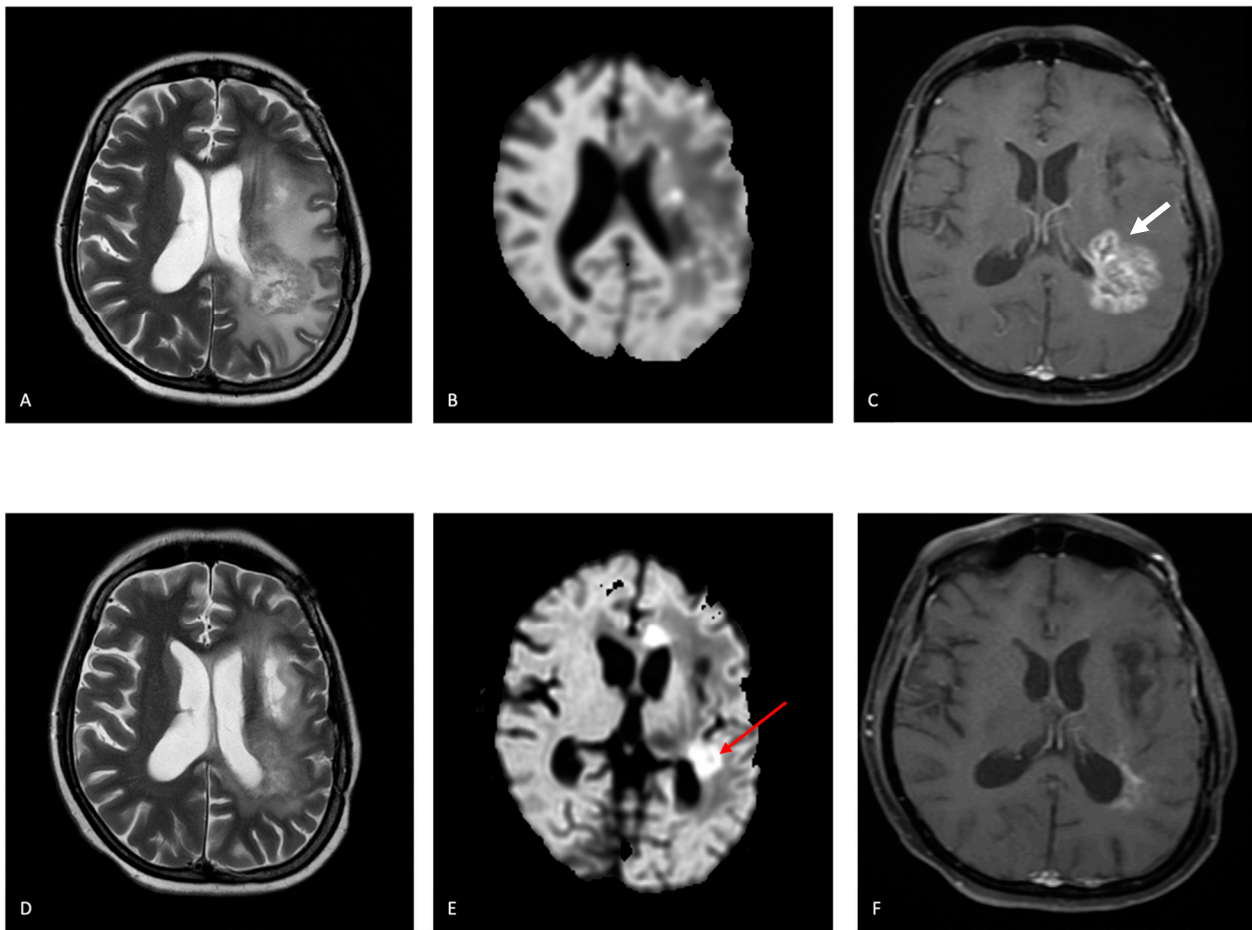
Tumor recurrence in a 47-year-old woman who underwent surgical resection and RT with temozolomide for infiltrating astrocytic tumor, IDH negative in the left parieto-insular region months earlier. (A) Axial T2-weighted image shows an intermediate lesion around the resection cavity. (B) The lesion is hypointense on a diffusion-weighted image. (C) Axial contrast-enhanced T1-weighted lesion with feathery enhancement consistent with recurrent disease (white arrow). Follow-up MR after 4 months post-two cycles of Bevacizumab. (D) Axial T2-weighted image shows a decrease in previously seen intermediate lesions. (E) The lesion (red arrow) shows restricted diffusion. (F) Axial contrast-enhanced T1-weighted lesion showing a decrease in the enhancing component suggestive of pseudoresponse.
